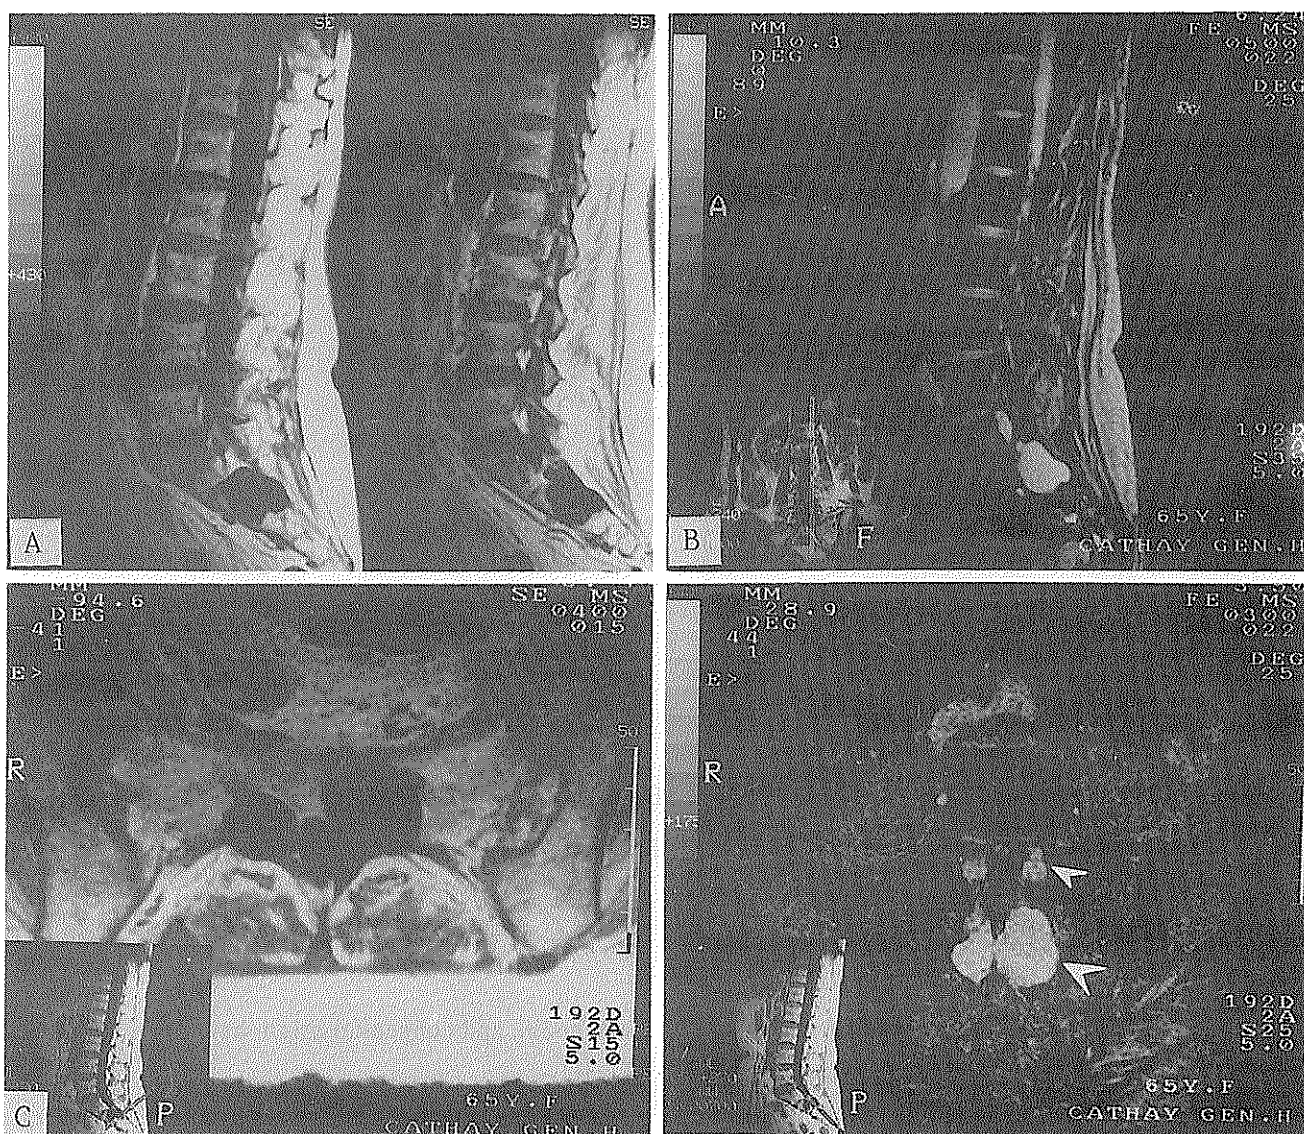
MRI sagittal scans demonstrating a large cyst in sacral canal, low signal in TIW image (A), and high signal in T2*W image (B); cysts with marked excavation of sacrum on axial TIW image (C); bilateral S1 (small arrowhead) and S2 (large arrowhead) cysts on coronal T2*W image (D).
